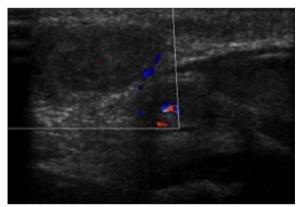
Ultrasound image of the left part of the interior inguinal canal, showing an ipsilateral testicle displaced cranially (top left). The left hemi-scrotum appeared to be occupied by the hematoma (bottom right) showing peripheral vascular spots.
